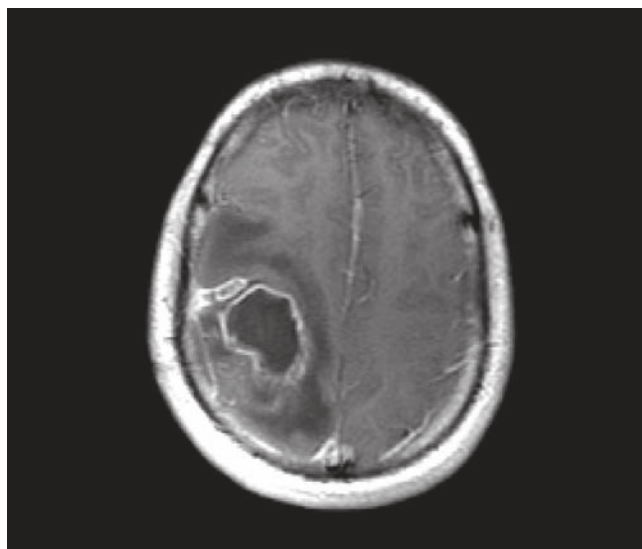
Gadolinium contrast-enhanced sequence magnetic resonance imaging, with an intracerebral lesion on the right parietal lobe which shows the “ring shape”.
